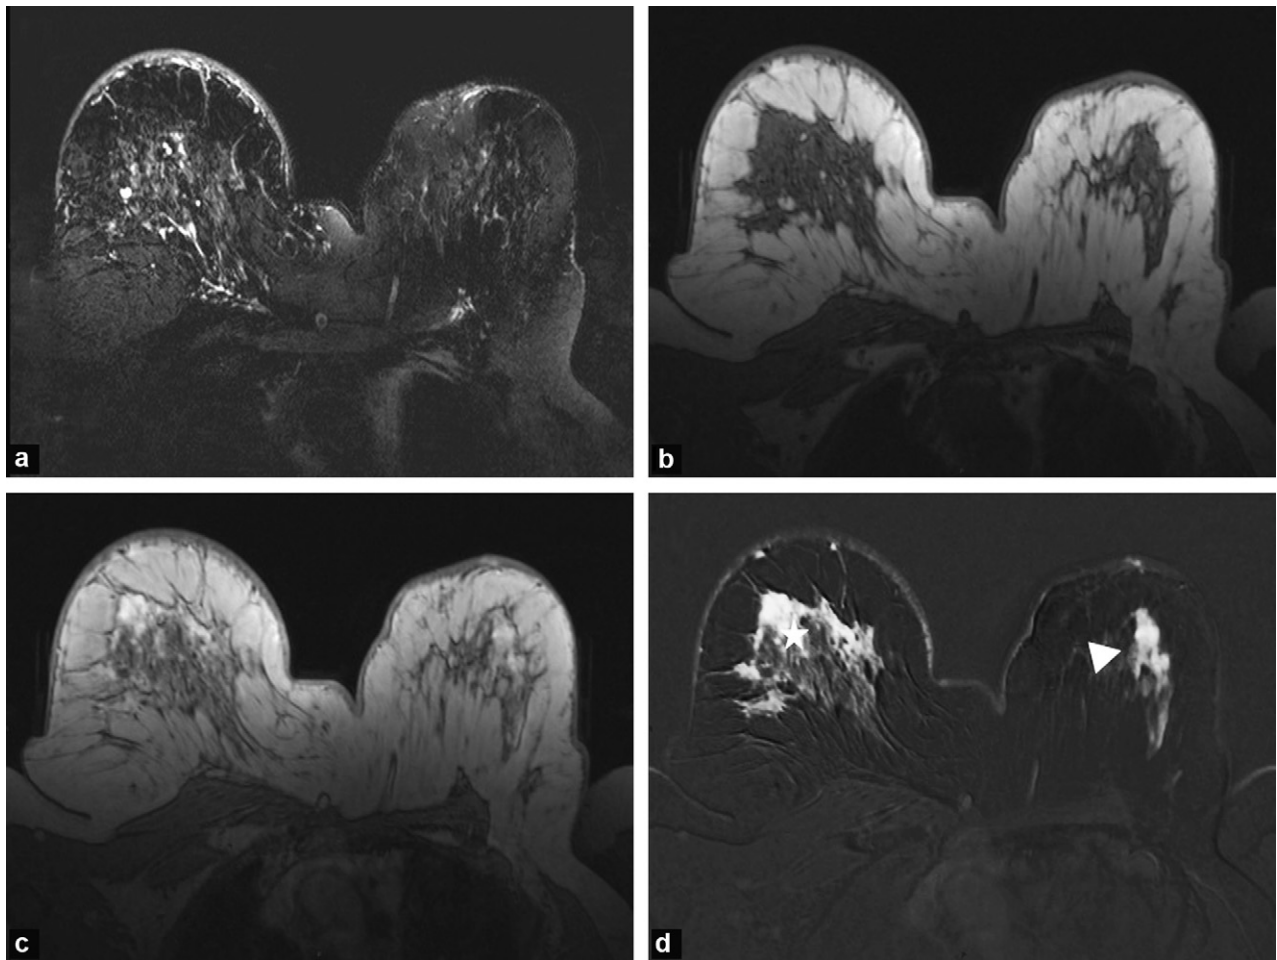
MRI appearance of an infiltrating ductal carcinoma (SBR grade II) of the right breast, clinically PEV 3. The MRI shows a cancer of the right breast in the form of a regional homogeneous non-mass (star) and skin thickening. On the left, the MRI shows homogeneous, segmental enhancement without a mass (ACR 4). A microbiopsy of this lesion of the left breast revealed an infiltrating ductal carcinoma (SBR grade II).
